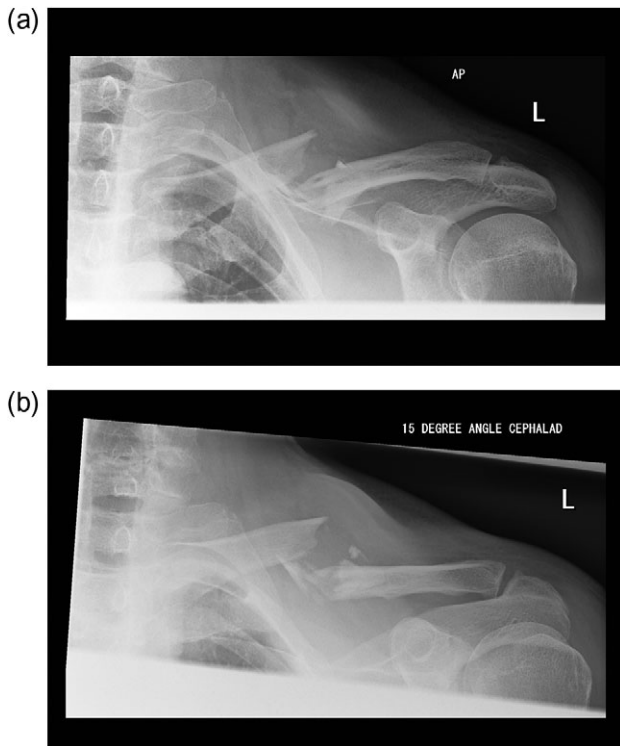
(a and b) Pre-operative radiographs of the fractured clavicle.
